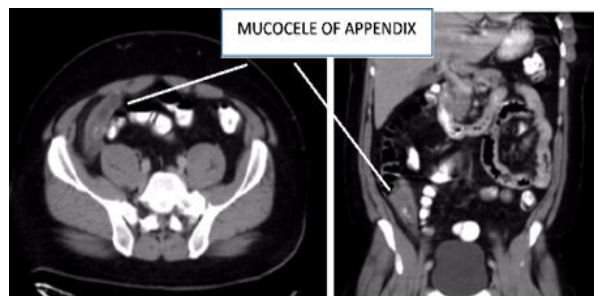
Mucocele of appendix on axial and coronal CT scan
